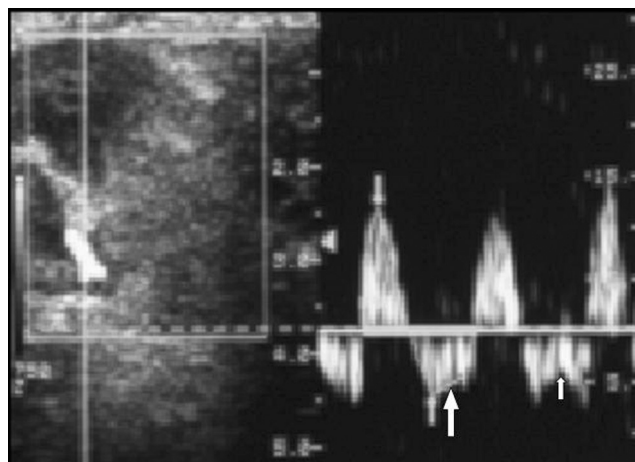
Doppler US at 2nd day shows reverse 'plateau-like' diastolic frequency shift (large arrow) and reverse 'inverted M' diastolic frequency shift (small arrow). Two patterns could be broadly regarded as the same pattern.
